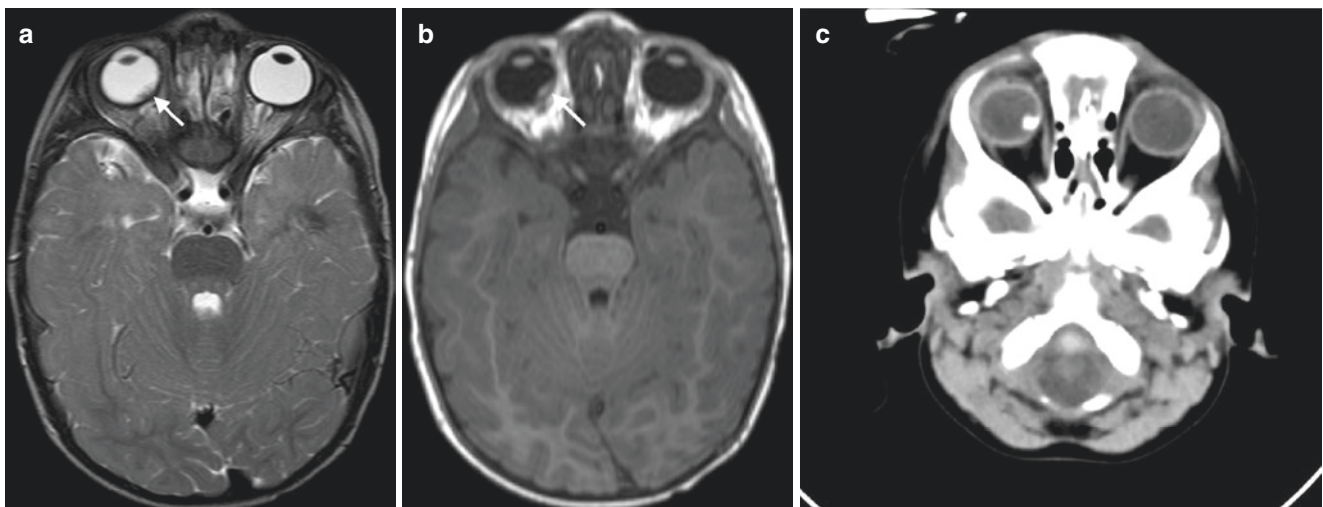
Retinoblastoma lesion within the right globe. The lesion (*arrow*) is low-signal on an axial T2-weighted MR image (a) high-signal on an axial T1-weighted image (b) and calcified on an axial CT image (c)
